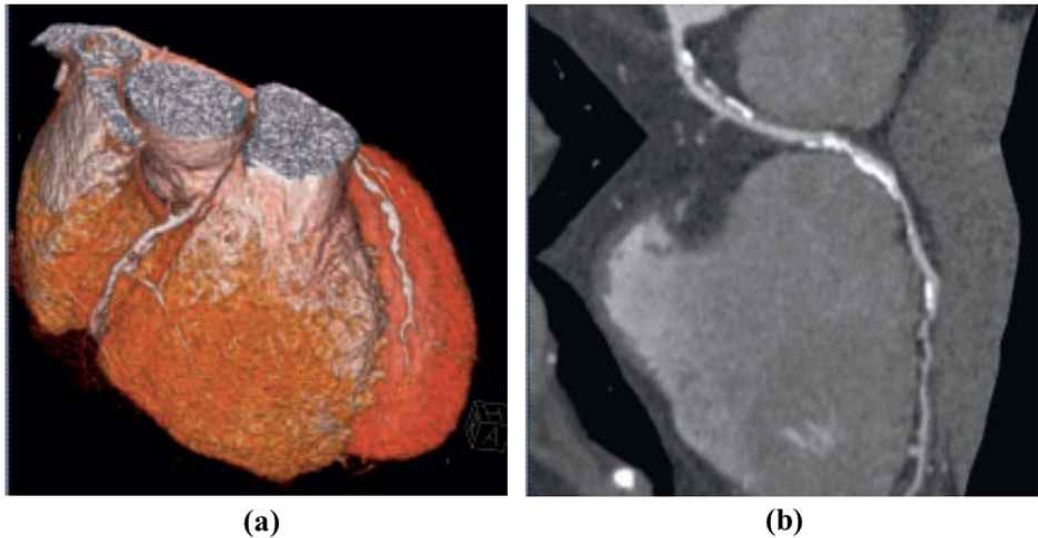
Courtesy of Siemens SOMATOM Sensation, CT Angiography of the Chest (a) Normal origin and course of right coronary artery seen (b) Diffuse plaque noted in the left coronary artery
